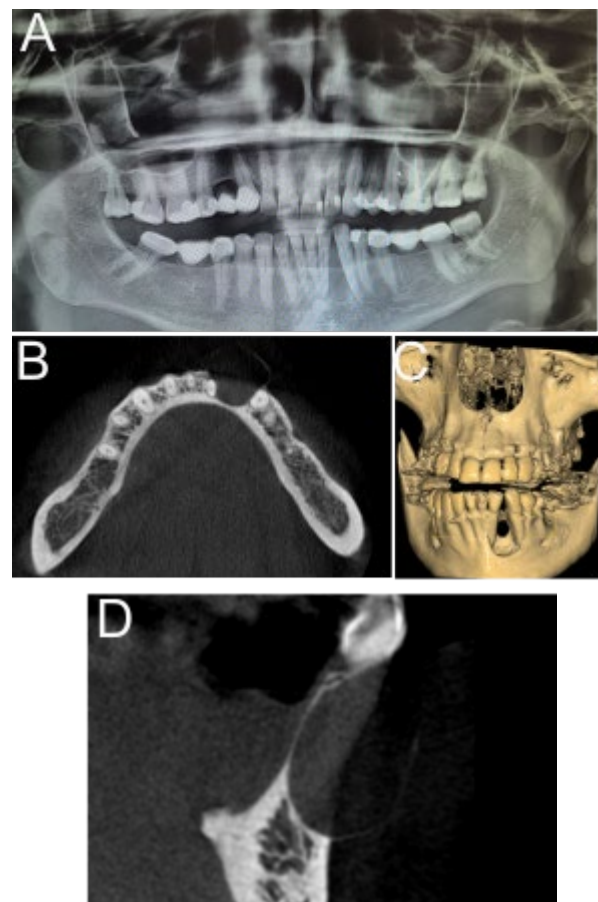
Radiographic findings. (A) Panoramic radiograph showing a well-defined, pear-shaped radiolucent lesion in the region of teeth 32 and 33, with slight tilting of the adjacent teeth; (B) Transversal CBCT measurements of the lesion, indicating mesiodistal, buccolingual; (C) 3D skull CBCT view showing the lesion's radiolucent area and its relationship to adjacent soft tissues; (D) Sagittal CBCT view demonstrating complete erosion of the buccal cortical plate and extension into the surrounding soft tissues and craniocaudal dimensions
